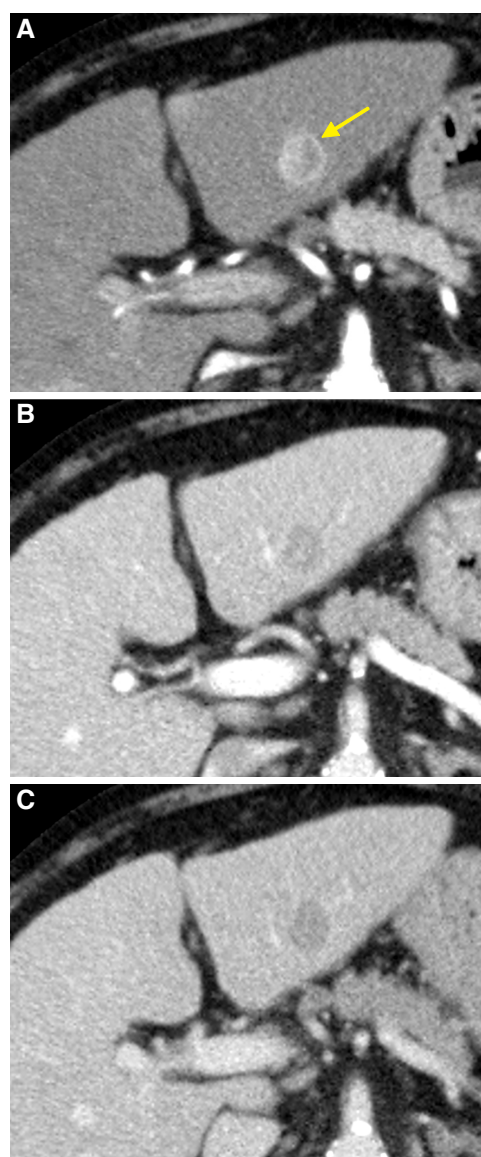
Computed tomography axial planes obtained in arterial phase (A), portal phase (B), and late phase (C). Lesion located in the segment III of left hepatic lobe, heterogeneous enhancement of the lesion is observed in the arterial phase (arrow in A) with washout in the portal and late phases. Mosaic pattern is shown in the arterial and portal phases (yellow arrow)
